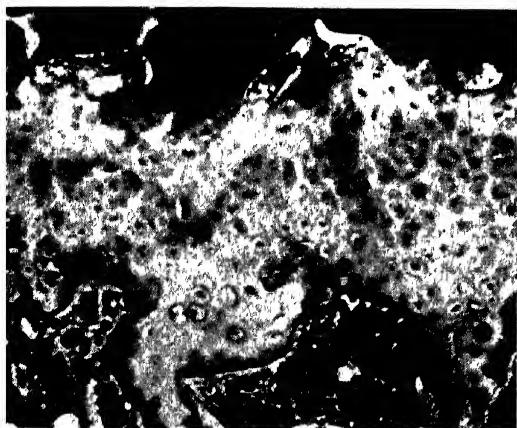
Epiphyseal plate 184 days after irradiation (1165 r). Columnar arrangement is completely disrupted and cartilage cells are swollen and varied in size. A thin plate of bone has been deposited along the metaphyseal margin of the epiphysis and calcified cartilaginous trabeculae are no longer evident.  $\times 140$ . (J. S. Barr, J. R. Lingley, and E. A. Gall: *Am. J. Roentgenol.*)
